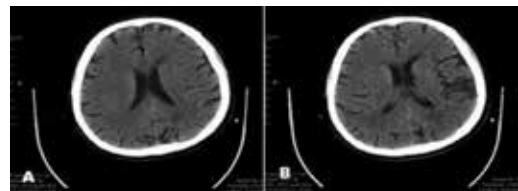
(A, B) Brain CT shows no hemorrhage CT: Computed Tomography.
